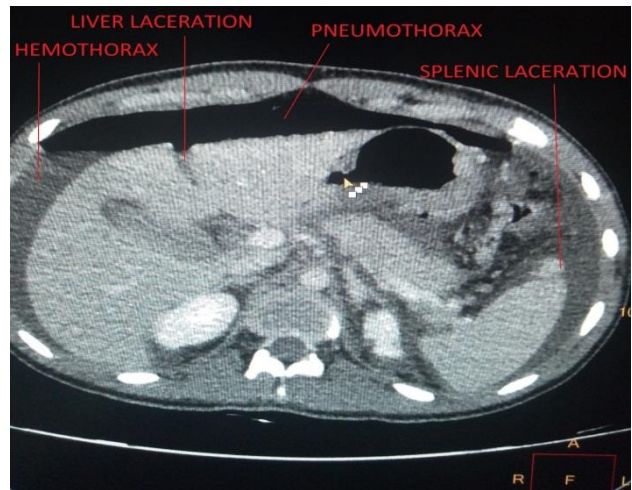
CT scan showing hemothorax, pneumothorax, liver laceration and splenic laceration.
